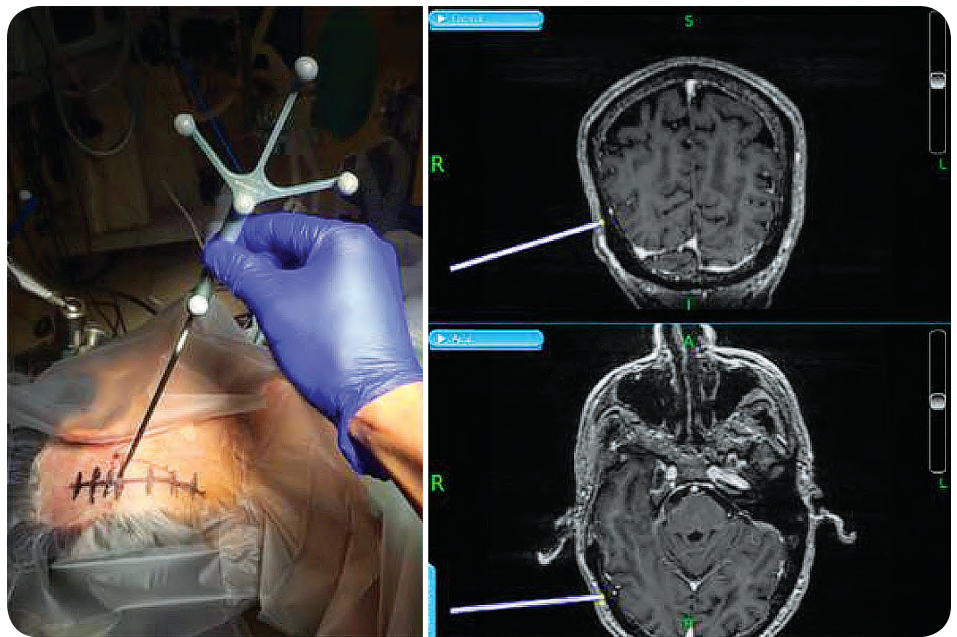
In the left panel, a stereotactic navigation probe has been placed on the scalp prior to prepping and sterile draping. In the top and bottom right panels, a virtual probe is shown on a preoperative MRI-based 3-D model of the head.
